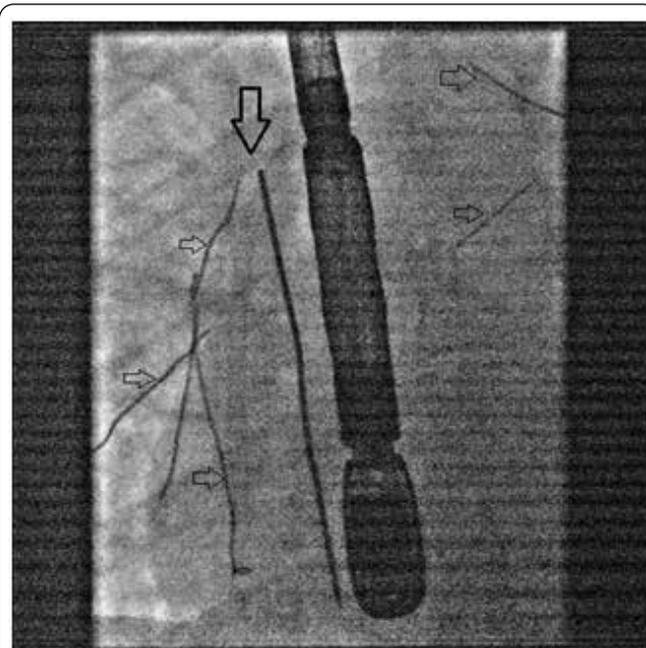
Fluoroscopy image taken during trans-oesophageal echocardiogram, demonstrating the motile object.
